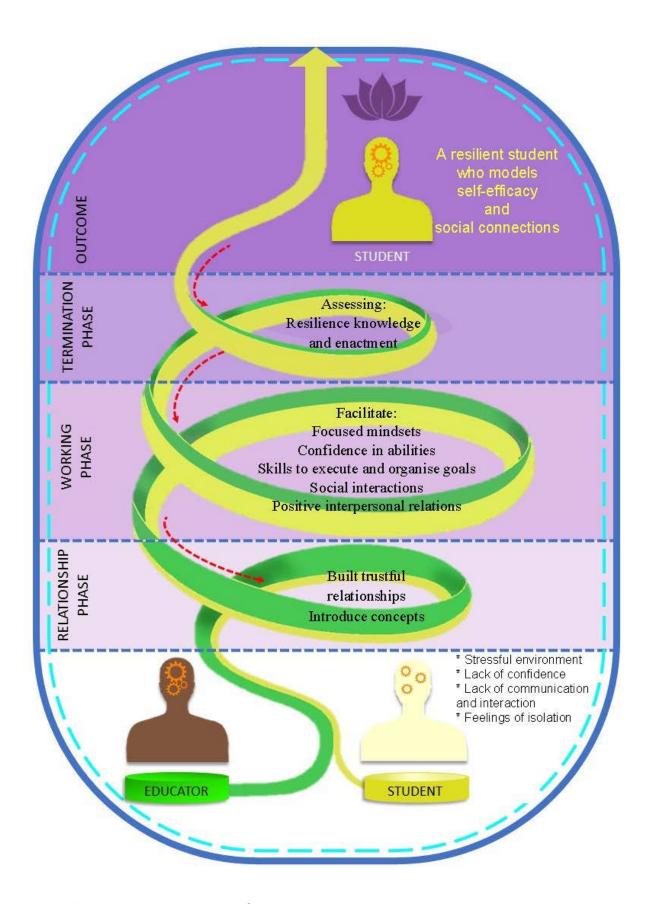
A model to facilitate resilience in radiography students.
